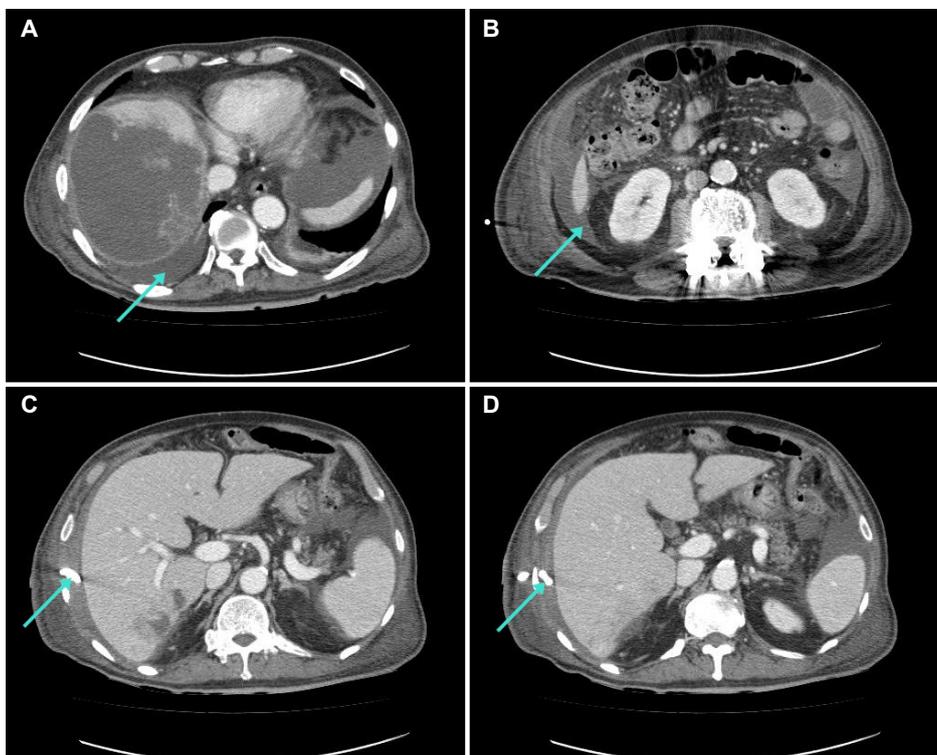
Computed tomography (CT) scan of the abdomen. (A, B) On hospital day 2, a CT scan revealed rupture of the liver abscess in the peritoneal cavity, pleural space, and pararenal space (arrow). (C, D) The percutaneous catheter drainage tip is located in the perihepatic space (arrow).
